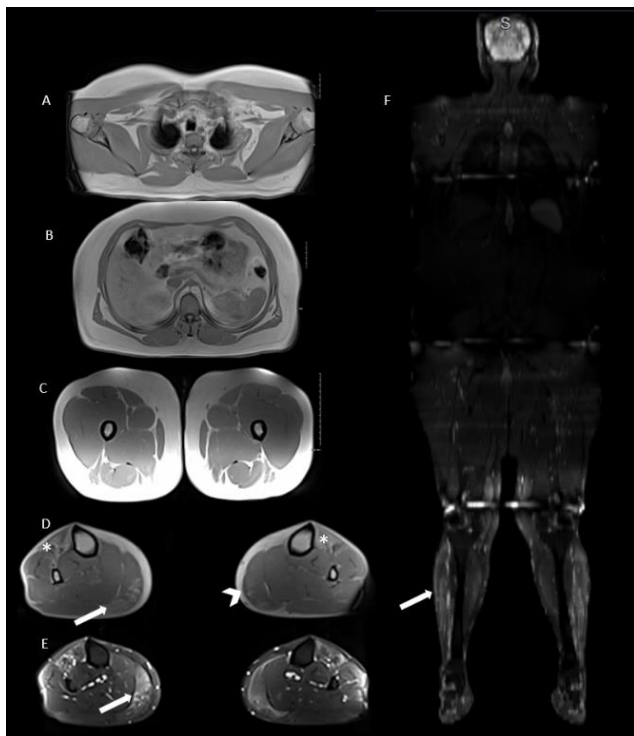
Muscle MRI in Facioscapulohumeral Muscular Dystrophy (FSHD) Presenting as Isolated Distal Myopathy (Patient 8.1).
